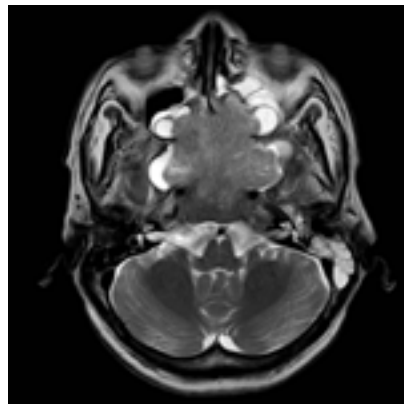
MRI (T2) axial – isointense sphenoid sinus mass lesion causing erosion of walls of sphenoid, clivus with infiltration of cavernous sinus and encasement of internal carotid arteries
